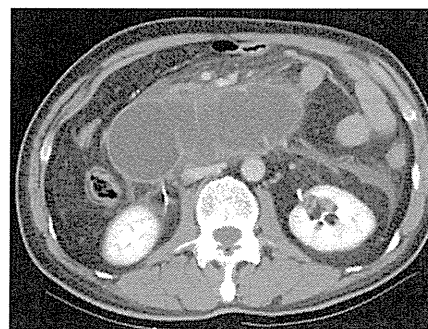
Abdominal CT scan demonstrated a markedly distended, fluid-filled afferent loop crossing the midline.
